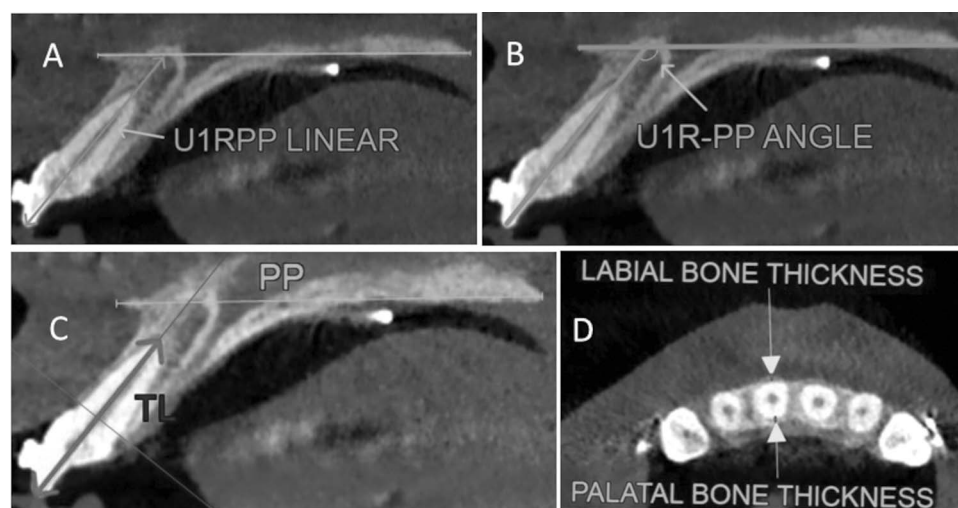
CBCT measurements: (A) vertical incisor position, (B) incisor inclination, (C) incisor total length, (D) labial and palatal bone thickness.
